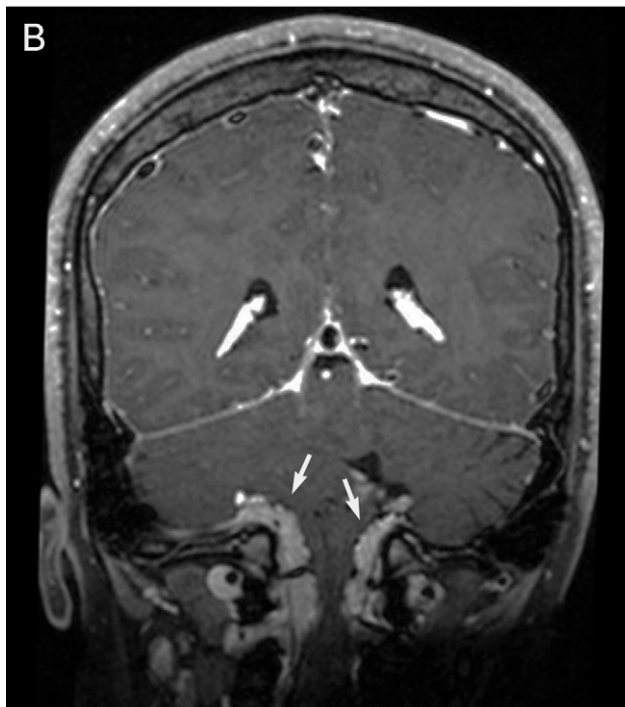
Meningiomatosis of the skull base. A: Postgadolinium axial MRI showing diffuse nodular thickening of the leptomeninges (arrows) extending bilaterally from the cerebellopontine angles. B: Postgadolinium coronal MRI showing the thickened leptomeningeal mass extending down through the foramen magnum and encasing the brainstem (arrows).
